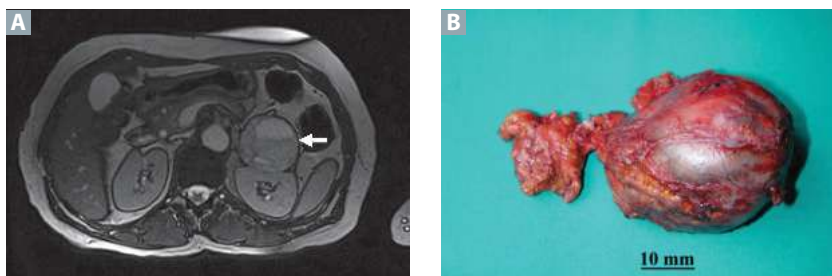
Pheochromocytoma. (A) MRI showing left suprarenal mass (*arrow*). (B) Pheochromocytoma postsurgical resection. (Reproduced with permission from Roghi A, et al. Adrenergic myocarditis in pheochromocytoma. *J Cardiovasc Magn Reson*. 2011;13:4)
